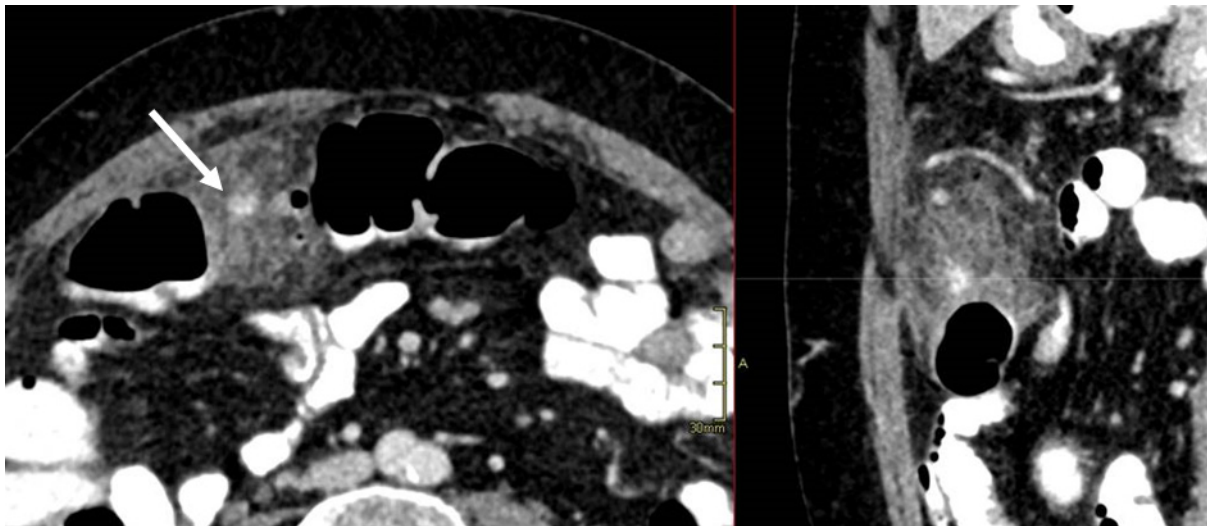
Axial (a) and sagittal (b) CT images, acquired in the portal venous phase, show focal fatty infiltration adjacent to the transverse colon. A central hyperattenuated focus (arrow in a), lacking colonic lumen continuity, likely represents a thrombosed vascular pedicle.
